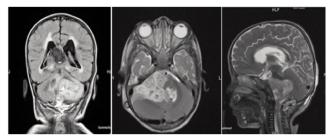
Post-operative MRI brain shows large posterior fossa mass extending into the cervical spinal canal up to the C2 vertebral body level.
